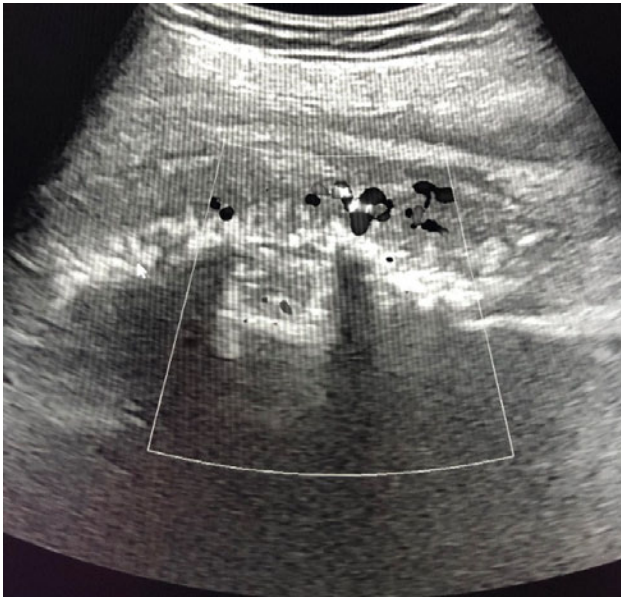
ultrasound of the femur - spicular periosteal reaction with irregular blood flow in the CFM image – mts of the bone
